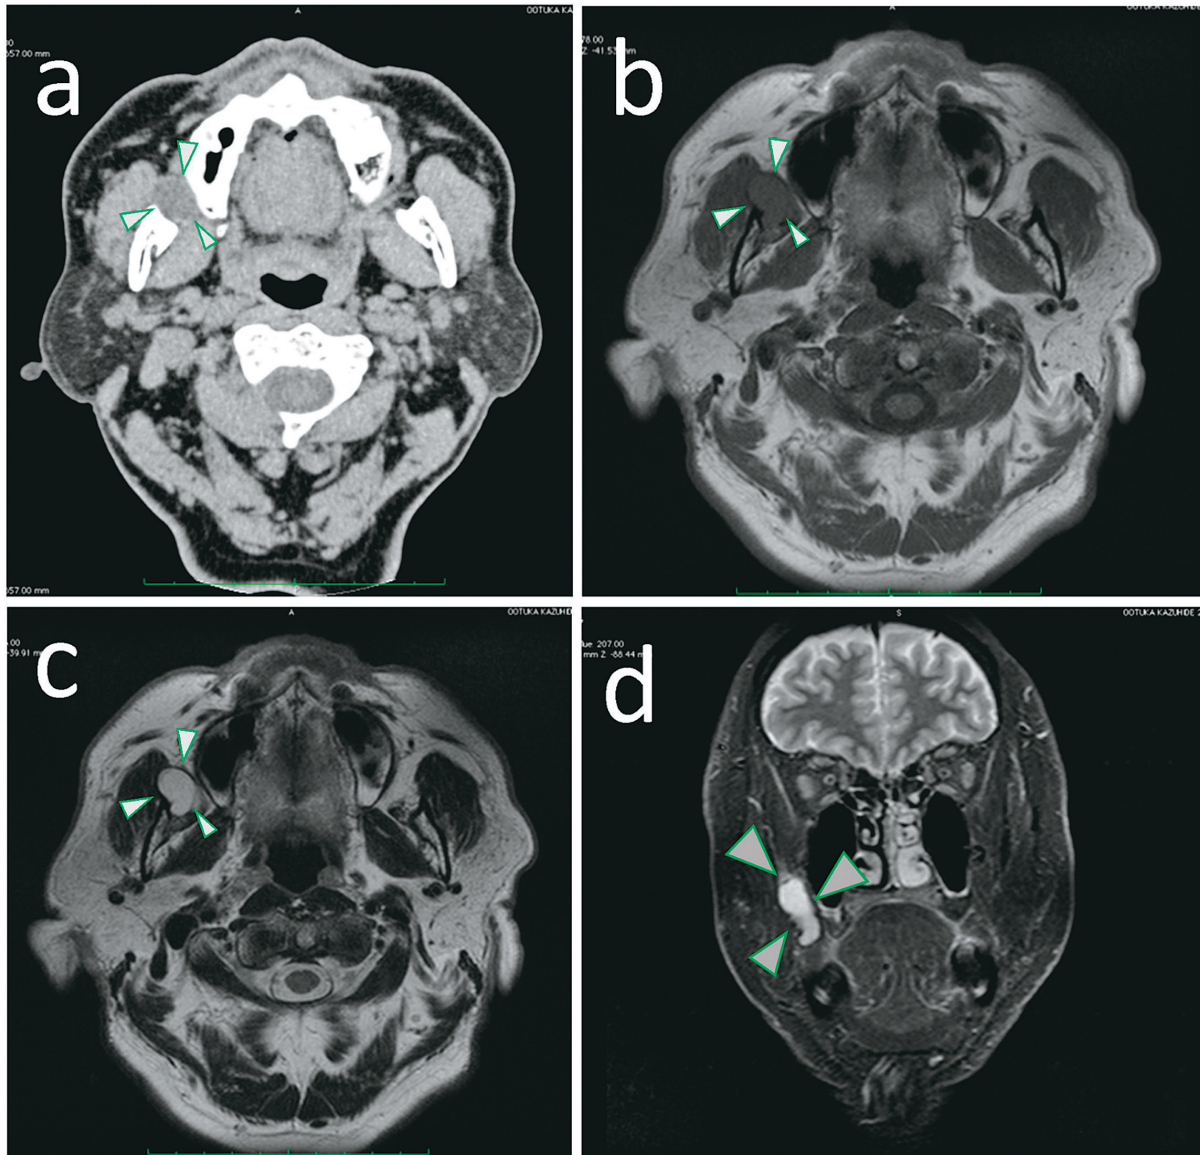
Radiographic findings. a) Axial CT, b) Axial MRI (T1), c) Axial MRI (T2), d) MRI (enhanced). A well-circumscribed low density mass is observed in the right buccal space in CT (arrow head). It shows a low signal on T1-weighted MRI and a heterogeneous high signal on T2-weighted MRI (arrow head). Enhanced MRI showed a well-circumscribed mass with homogenous internal structure.
